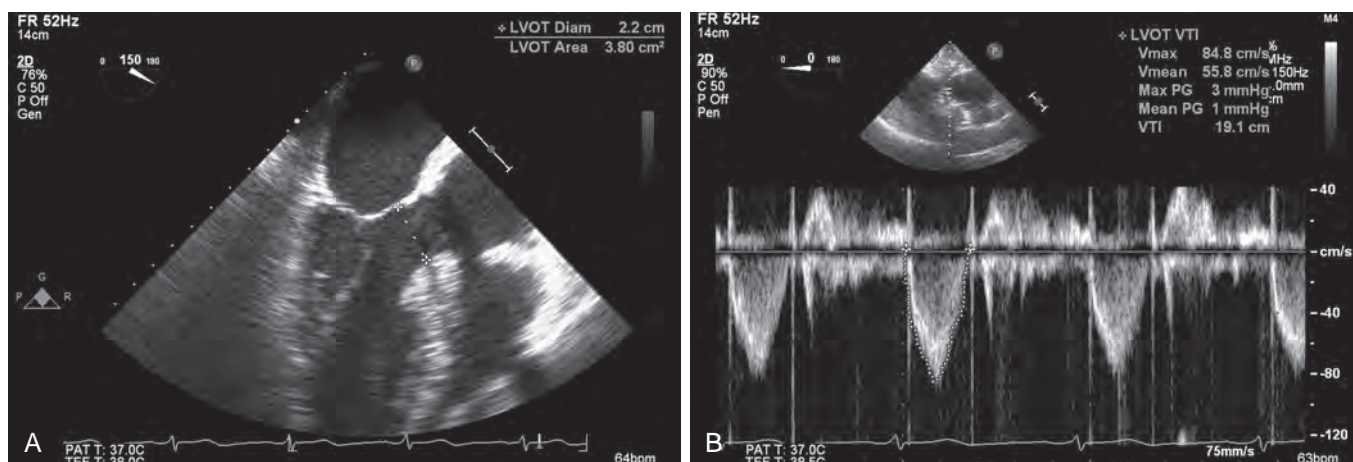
Calculation of cardiac output. (A) Midesophageal long-axis view. The diameter of the left ventricular outflow tract is measured. (B) Velocity time integral through the left ventricular outflow tract. Since spatial specificity is necessary, a pulsed-wave Doppler spectrum is used.
